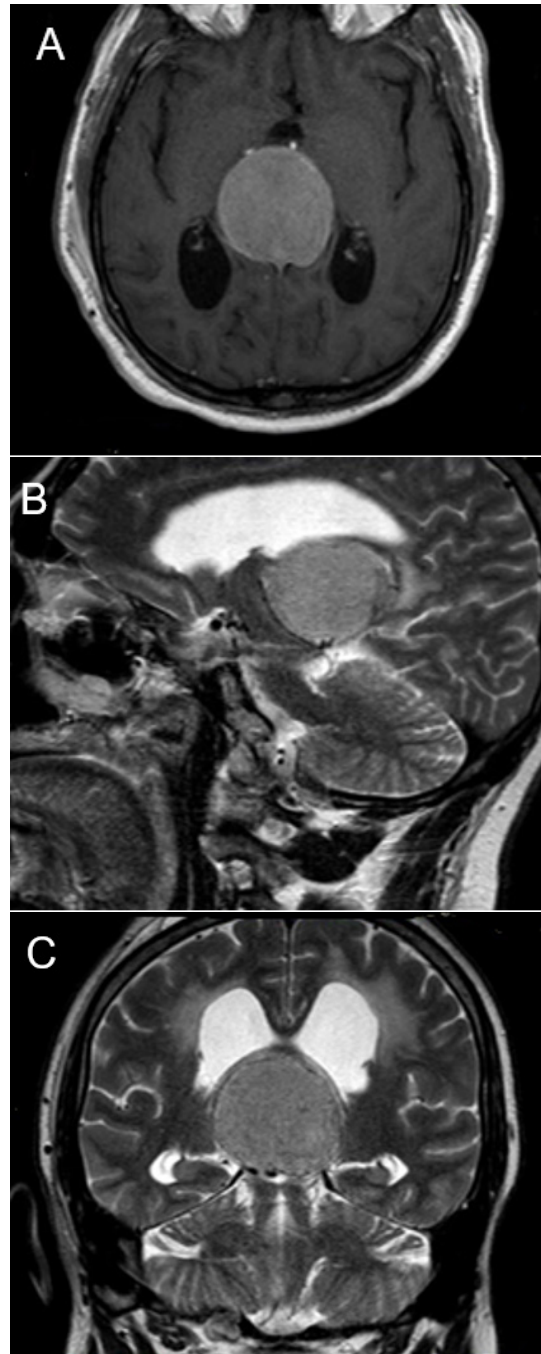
Preoperative axial T1 (A), sagittal T2 (B) and coronal (C) T2 MR images showing the pineal region meningioma, 42 x 43 x 38 mm in diameter, hypointense in T1 and hyperintense in T2 sequences, with the deep venous system displaced inferiorly.
